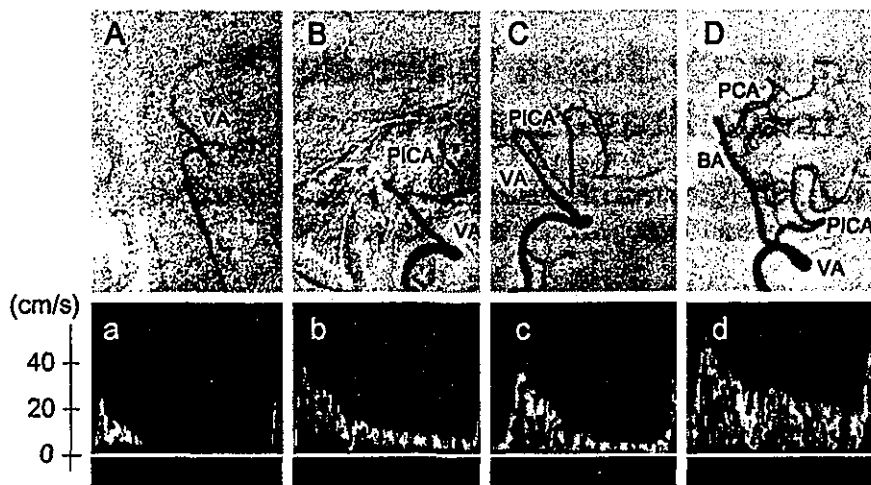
Angiogram (lateral view of vertebral arterial angiography) and Doppler waveforms of patients in the Before group (A and a), After group (B and b), PICA end group (C and c), and Control group (D and d). A and a, The VA was occluded before branching into the PICA. The Doppler waveform showed no EDV. B and b, The VA was occluded after branching into the PICA. The Doppler waveform showed EDV and MV was lower than those of the Control group. C and c, The VA ended in the PICA and did not continue to the union of the BA. The Doppler waveform also showed EDV and MV were lower than those of the Control group. D and d, No significant occlusion of the VA. The Doppler waveform showed EDV and MV was highest among all groups. VA indicates vertebral artery; BA, basilar artery; PICA, posterior inferior cerebellar artery; PCA, posterior cerebral artery.
